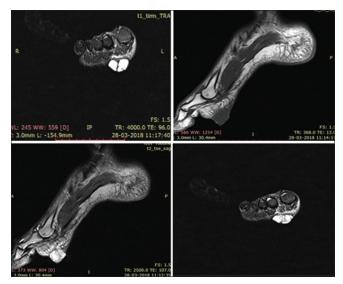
Magnetic resonance imaging right foot
